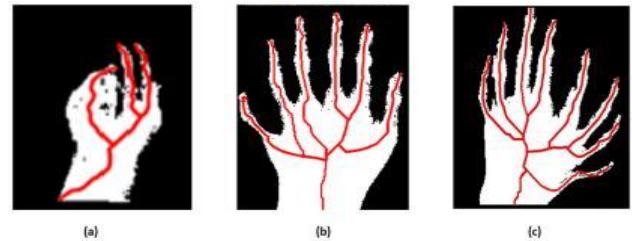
Finger count results: (a) three-digit abnormal count using skeletonization on pre-processed syndactyly radiograph, (b) six-digit finger count on preprocessed polydactyly syndrome radiograph, (c) eight-digit finger count polydactyly abnormality
